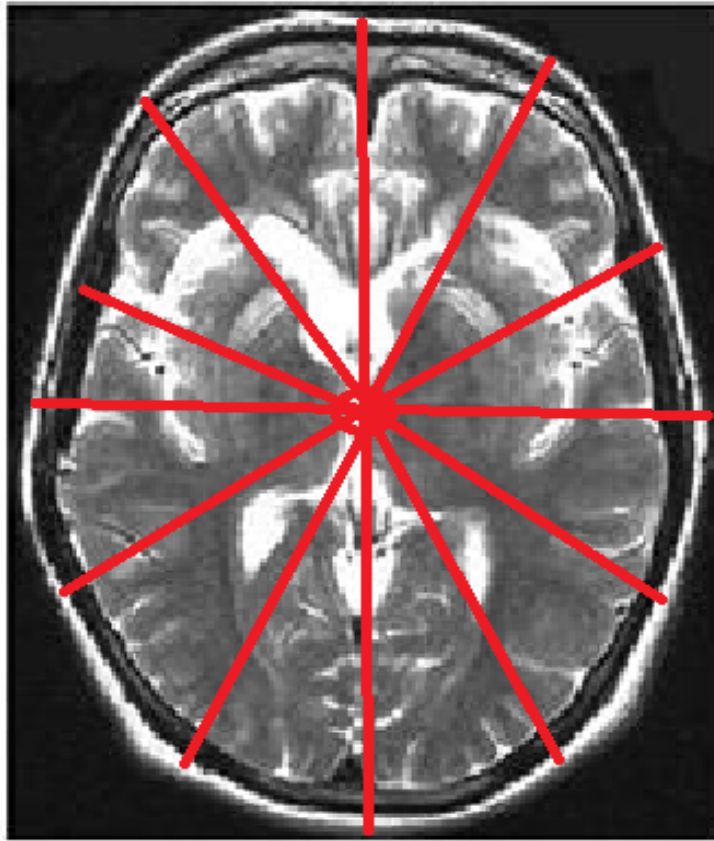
Each MRI slice in a MRI volume is transformed from the original cartesian coordinate system to cylinder coordinate system of unit radius $r = 1$ and height T .
